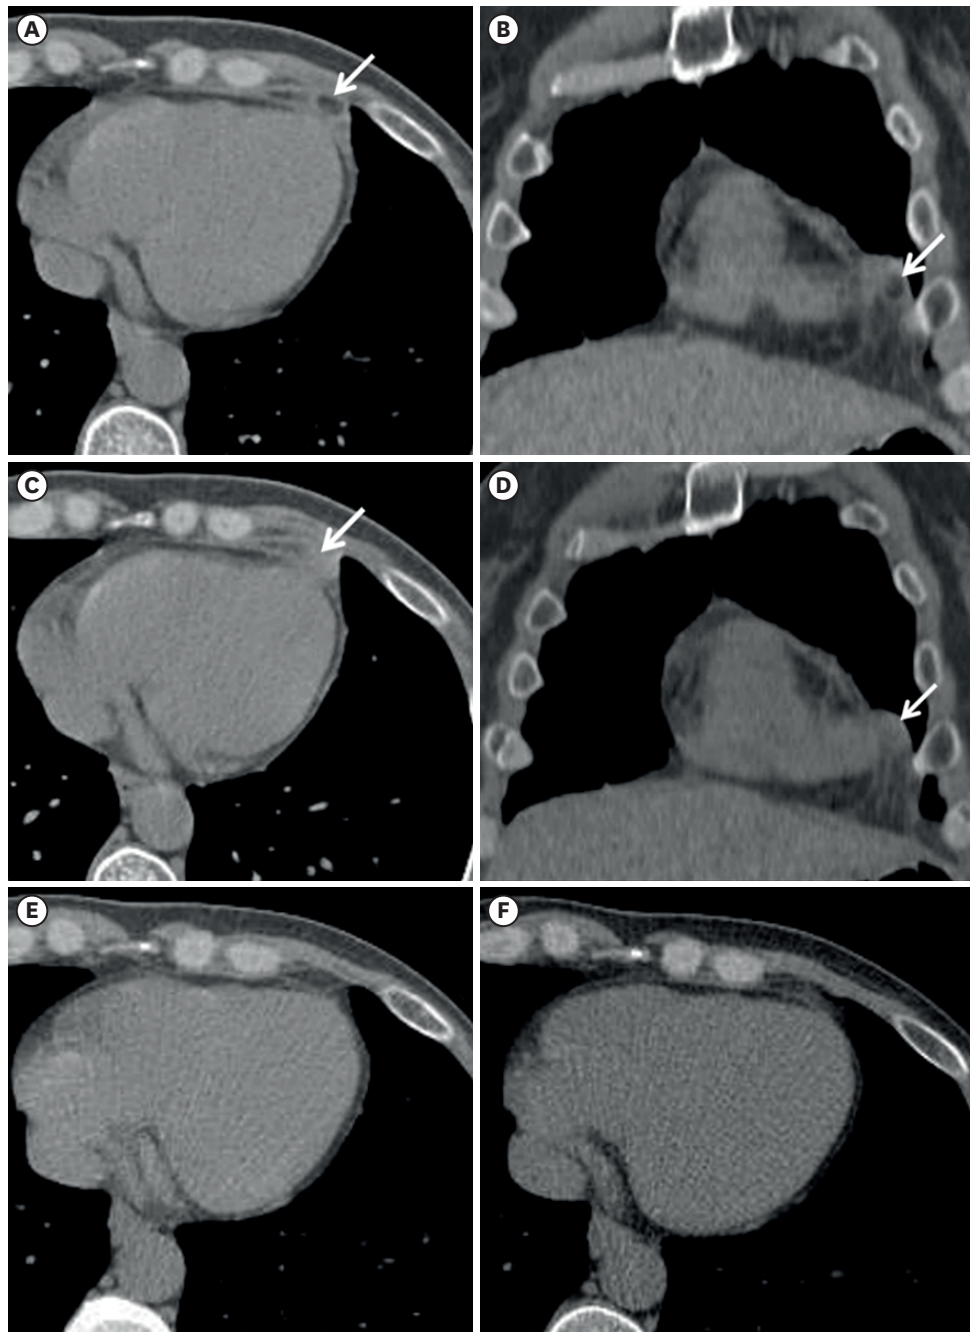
(A) Axial and (B) coronal low-dose radiation CT images in a patient who had experienced a left-sided pleuritic chest pain one week earlier show a nodular fatty lesion in the epipericardial fat (arrow). (C) Axial and (D) coronal CT images demonstrate a focal stranding of the adjacent mediastinal fat (arrow). The combination of a nodular/ovoid fatty lesion with surrounding stranding of the epipericardial fat pad in the cardiophrenic space is the main radiological finding of EFN on CT. (E) A previous chest CT performed one year earlier showed a normal epipericardial fat pad. (F) A thoracic CT performed 3 months after the diagnosis of EFN shows a normal epipericardial fat pad.
